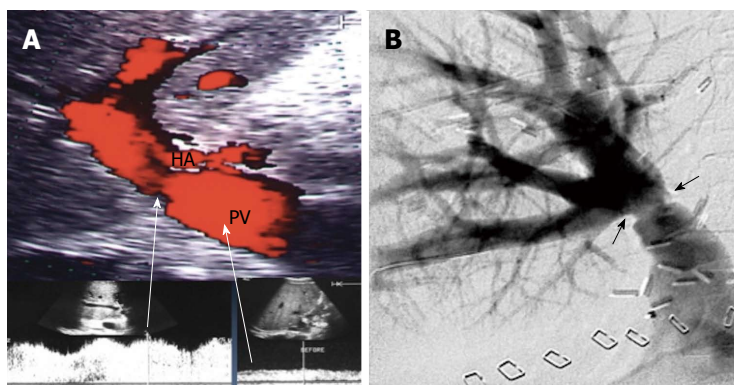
Portal vein pseudo-stenosis in a clinically silent patient. A: Post-operative color Doppler image, 2 mo post living donor liver transplantation demonstrating anastomotic stenosis 50%-60%, with elevation of the anastomotic velocity (4-fold) compared to the pre-anastomotic velocity; B: Percutaneous trans-hepatic digital subtraction portography image, showing anastomotic stricture (arrows) however, the pressure gradient across the anastomosis was 3 mmHg and angioplasty and stent placement were not performed. PV: Portal vein; HA: Hepatic artery.
